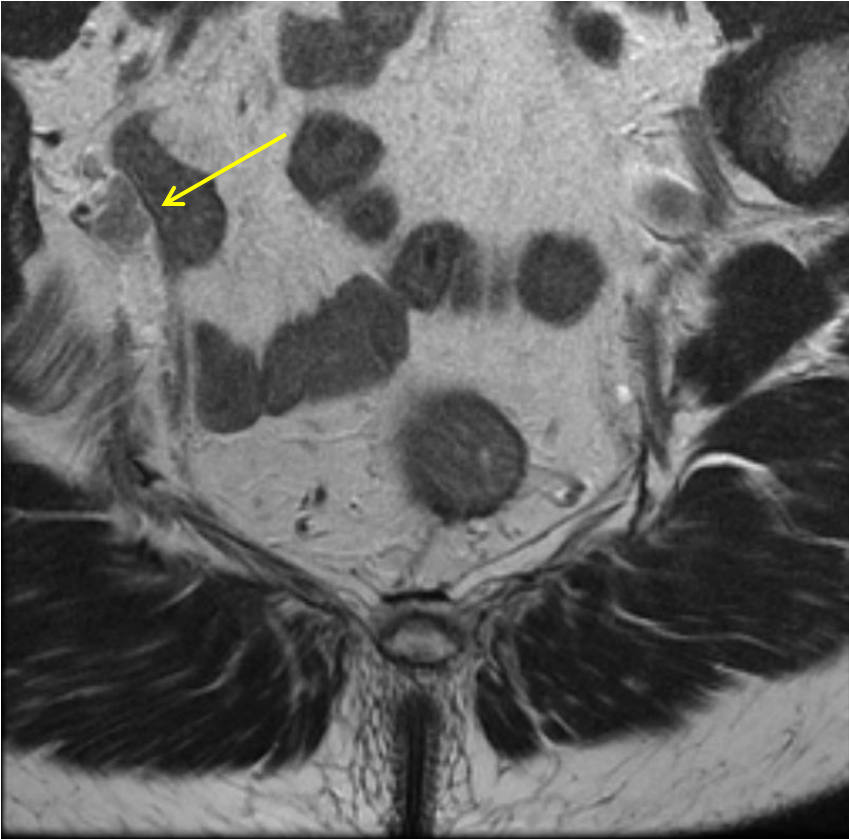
(Case 170) Coronal MRI images of a 52-year old male patient with a locally advanced lower rectal cancer staged cT3dN2b with positive lateral pelvic lymph nodes (yellow arrow points to these pathological lymph nodes); a nearly-complete pathological response was obtained after neoadjuvant chemoradiotherapy
